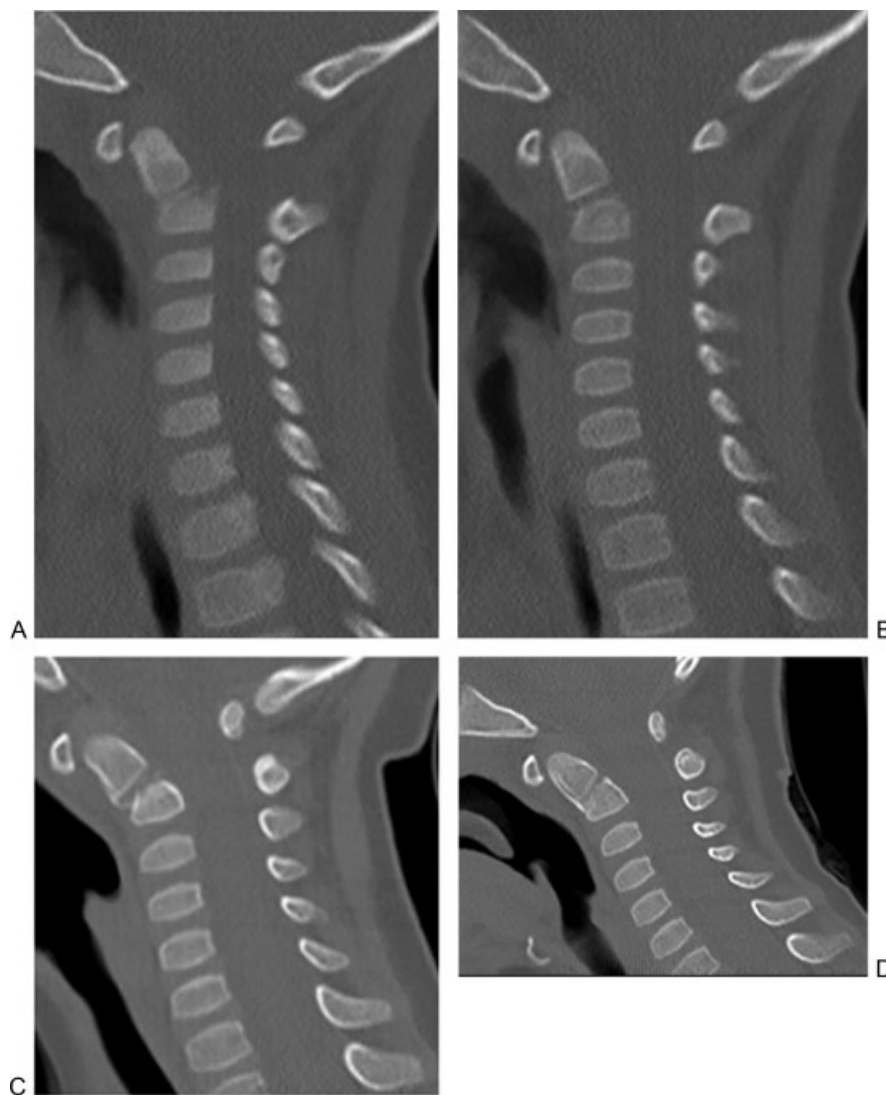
Serial sagittal computed tomography images of a conservatively managed odontoid process fracture in a 2-year-old: (A) 45 degrees at initial presentation; (B) 45 degrees at 6 weeks postinjury with callus formation; (C) 40 degrees at 10 weeks postinjury; (D) 25 degrees at 6 months postinjury.
